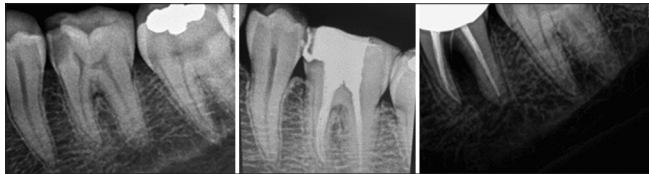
Radiographs showing pre-RCT, immediately after RCT, and 3 months post-RCT. RCT: Root canal treatment
